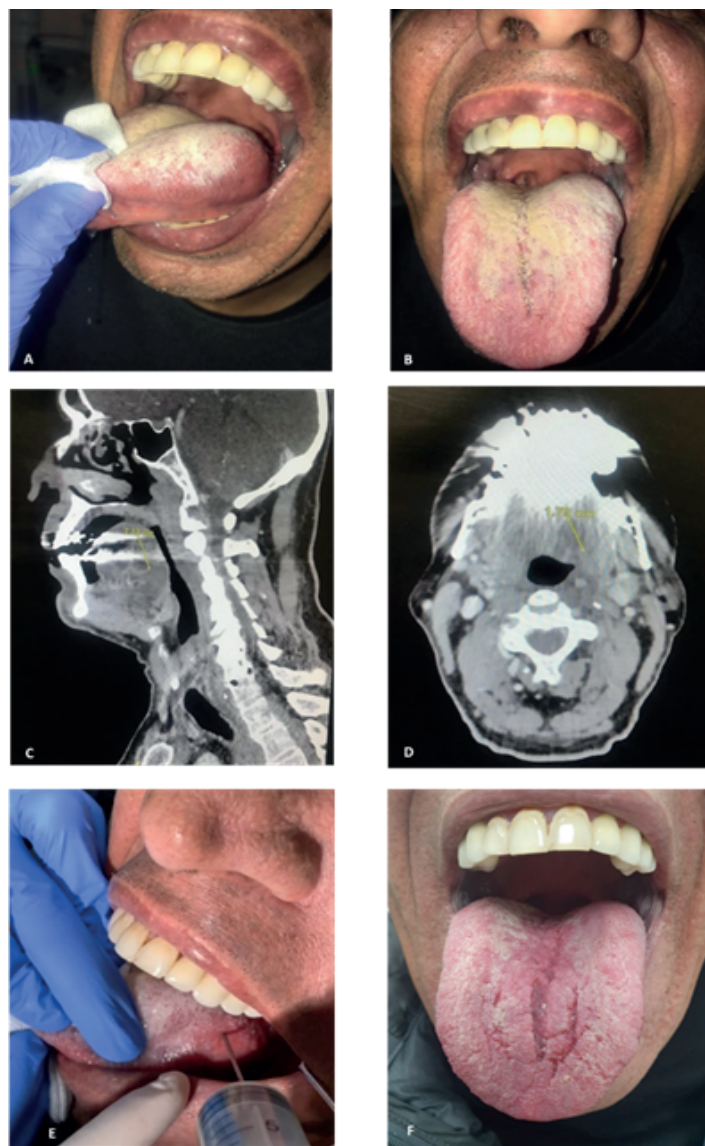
A and B) Swelling of the tongue at first patient presentation. C and D) Sagittal and Axial CT with contrast at level of tongue. Lingual abscess is demonstrated as rim-enhanced lesion with central hypo-dense cavity. E) large-bore needle aspiration showed isolated pus from the tongue swelling. F) Presentation of the patient after 5 days with complete recovery.
